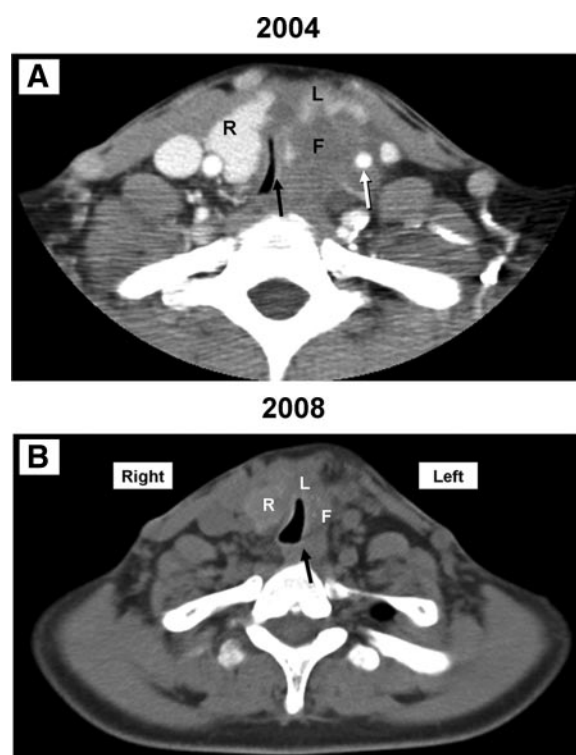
Computed tomographic images of the neck. A, Image taken with contrast (2004). Note partial involvement of the left lobe with fibrosis (F), extrathyroidal extension, and significant tracheal narrowing (*black arrow*) and engulfment of the common carotid artery (*white arrow*). Also note the uninvolved part of left lobe (L). The right lobe of the thyroid (R) is completely uninvolved. B, Image taken without contrast (2008). Note the stability and partial resolution of the process in the left lobe. (F denotes partially resolved left lobe fibrosis; L, uninvolved part of the left thyroid lobe; R, right lobe. The *black arrow* shows improved tracheal narrowing.)
